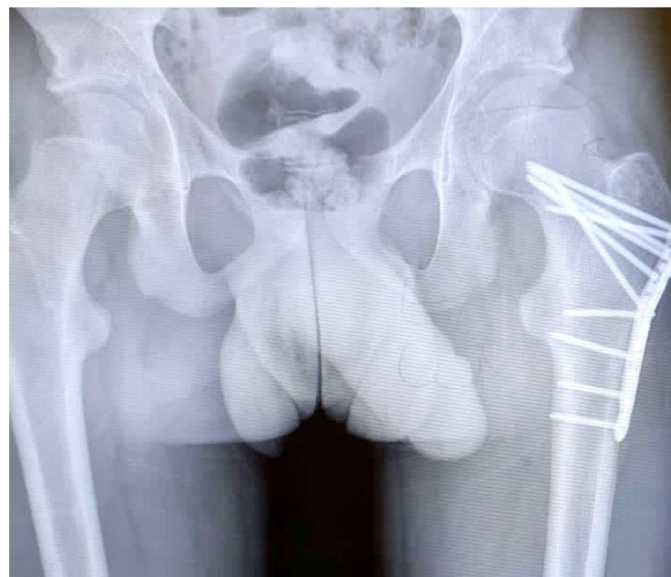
X-ray at fourth-year post-operative showing fracture healing without complications
